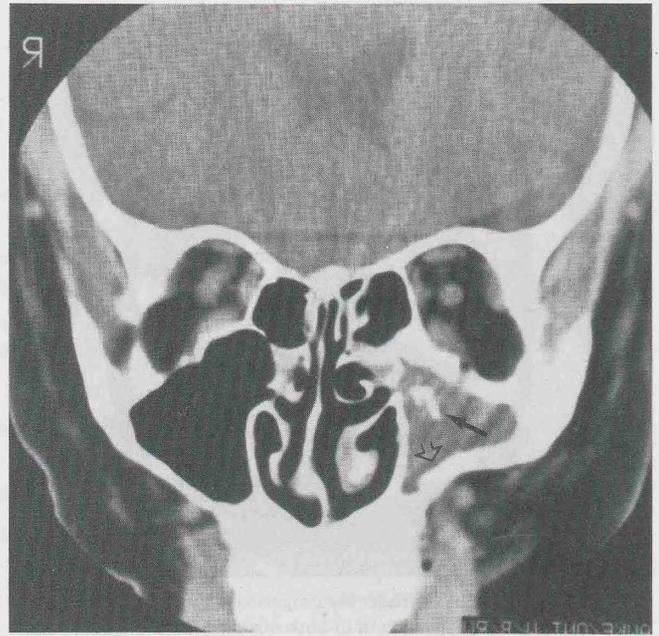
Non-enhanced CT scan on the same patient of Figure 3A demonstrates focal area of calcification (arrow) in the left maxillary sinus, which shows sinusitis and reactive osteitis (open arrow).
